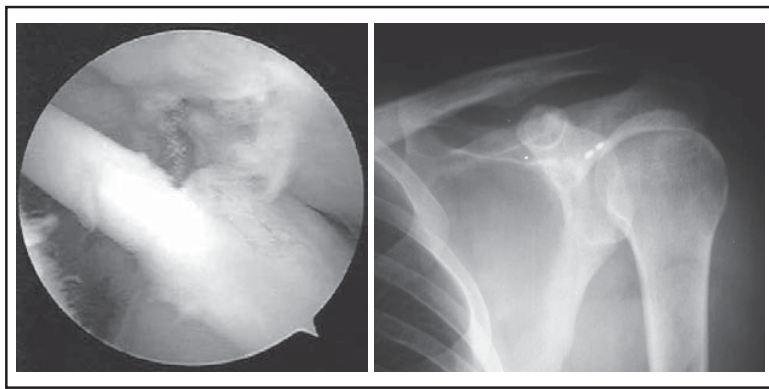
Type II SLAP tear suture anchor repair – arthroscopic image & postoperative radiograph
